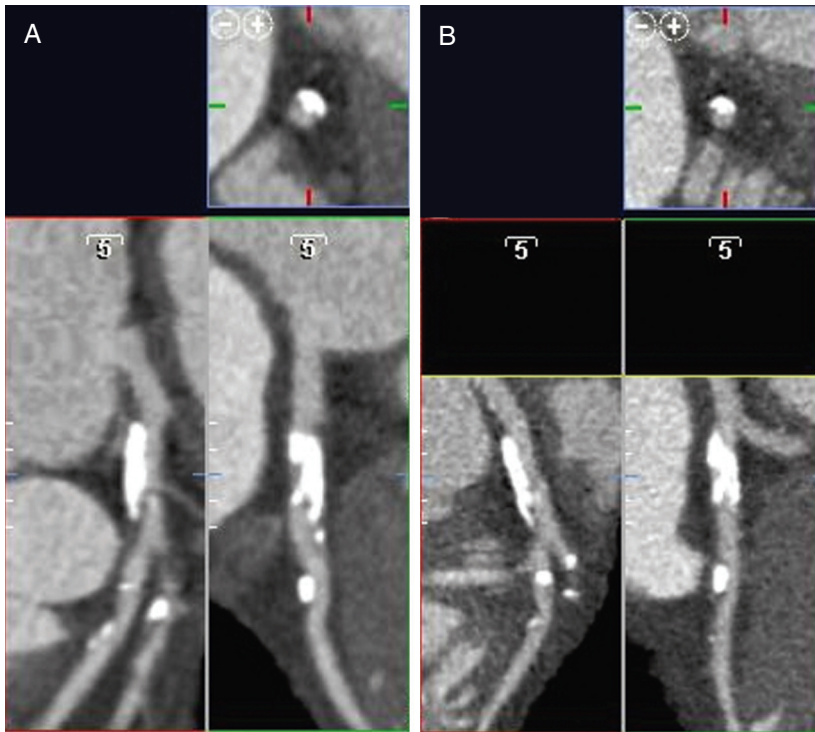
Reconstruction of CT data using two different reconstruction “kernels.” In A, a soft or smoothing reconstruction kernel is used. By comparison, the sharp kernel in B produces a more grainy image. The sharp kernel results in an image with more edge definition between high- and low-attenuation material or structures such as coronary calcium.
